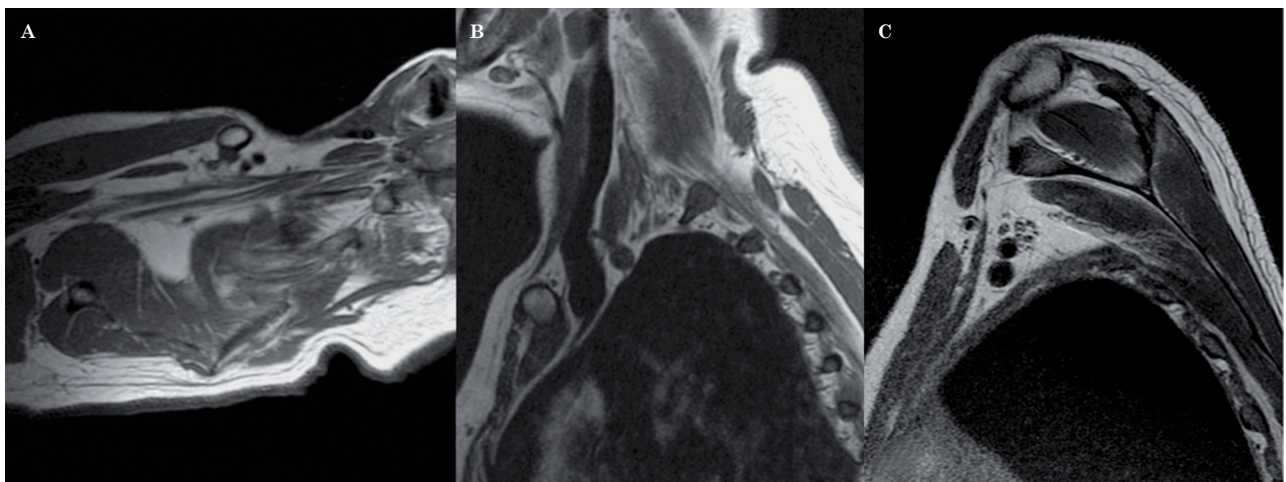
Normal anatomy of the brachial plexus. A T1-weighted sequence in the axial oblique plane (A) shows the roots, the trunks and the divisions of the brachial plexus in a continuous fashion, surrounded by fat. Sagittal oblique T1-weighted images demonstrate the roots within the scalene triangle (B) and the cords in the axillary region (C).
